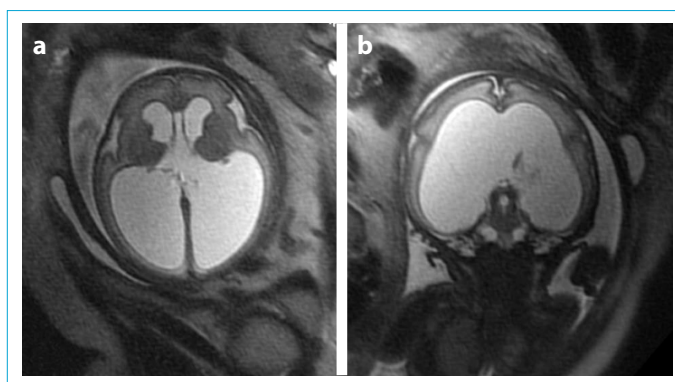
(a, b). Axial (a) and coronal (b) T2-weighted MRI show significant dilatation of the lateral ventricles.
